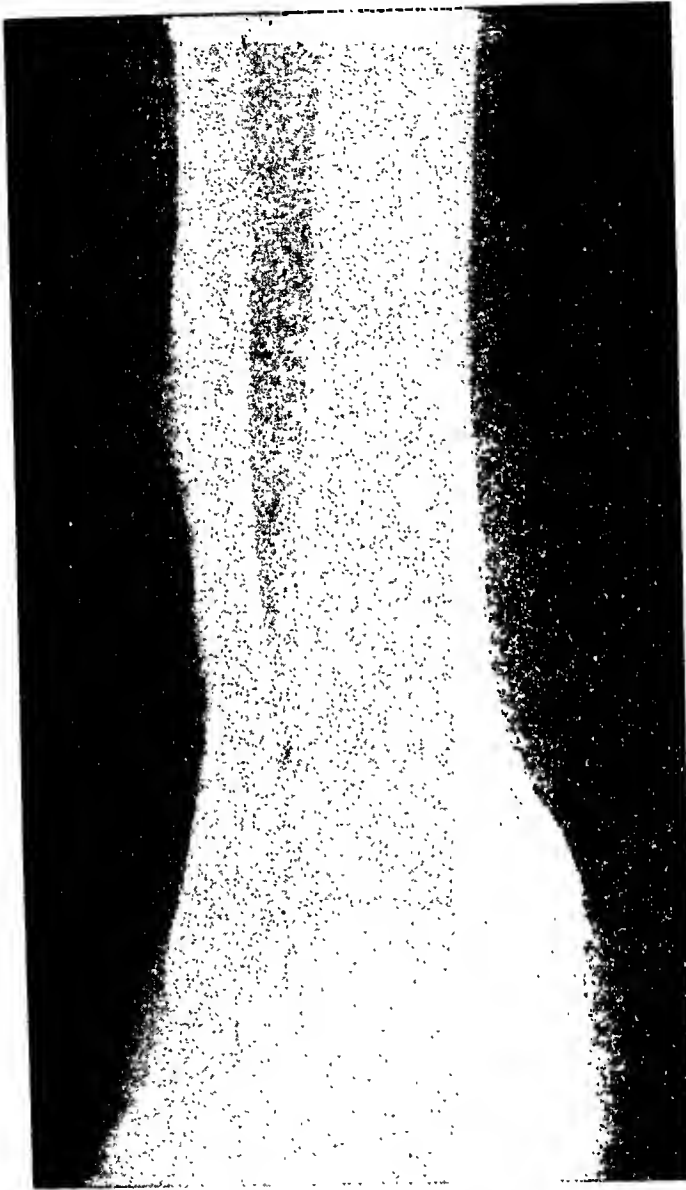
Roentgenological study of right lower extremity. Note marked periosteal irregularity of both tibia and fibula.
